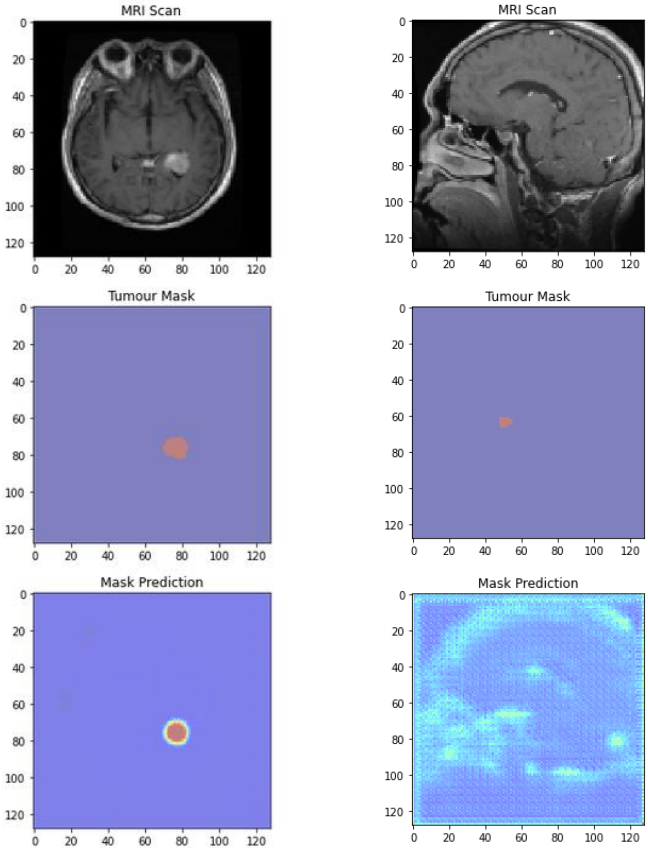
Plots of MRI Scan, Tumour Mask, Successful Mask Prediction
